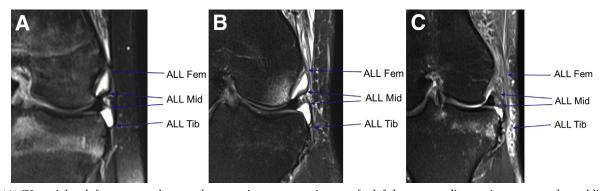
(A) T2-weighted, fat-saturated coronal magnetic resonance image of a left knee revealing an intact anterolateral ligament with all 3 main anatomic regions clearly visible, including the anterolateral ligament femoral attachment (ALL Fem), ALL mid-substance (ALL Mid), and ALL tibial attachment (ALL Tib). (B) T2-weighted, fat-saturated coronal magnetic resonance image of a left knee revealing a partially torn anterolateral ligament evidenced by the enhanced fluid signal along and surrounding the ligament, most notably along the femoral-sided attachment site (ALL Fem) and ALL Mid. The ALL Tib site is intact with less fluid enhancement signal. (C) T2-weighted, fat-saturated coronal magnetic resonance image of a left knee revealing a completely torn anterolateral ligament at the femoral and meniscal attachment. There is no recognizable ligament substance in the ALL Fem or the ALL Mid region. The ALL Tib shows a poorly defined ligament attachment.
